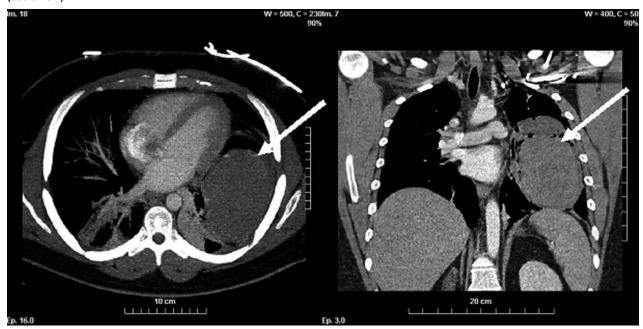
CT scan of the chest: big cystic formation (14 cm) in the left lower lobe with intracystic bleeding following thoracic drainage and reexpansion of the lung (see arrow).
